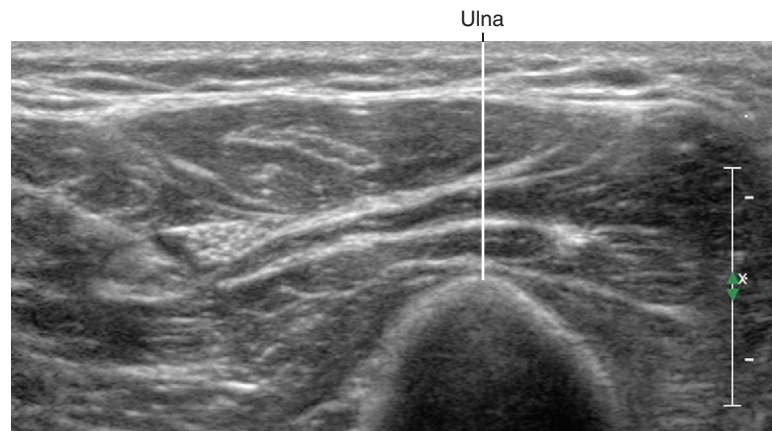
Acoustic shadowing by bone. In this sonogram from the forearm, the acoustic shadowing by the ulna is evident. The bright cortical line of the surface of the bone is followed by extinction of the sound wave below.
